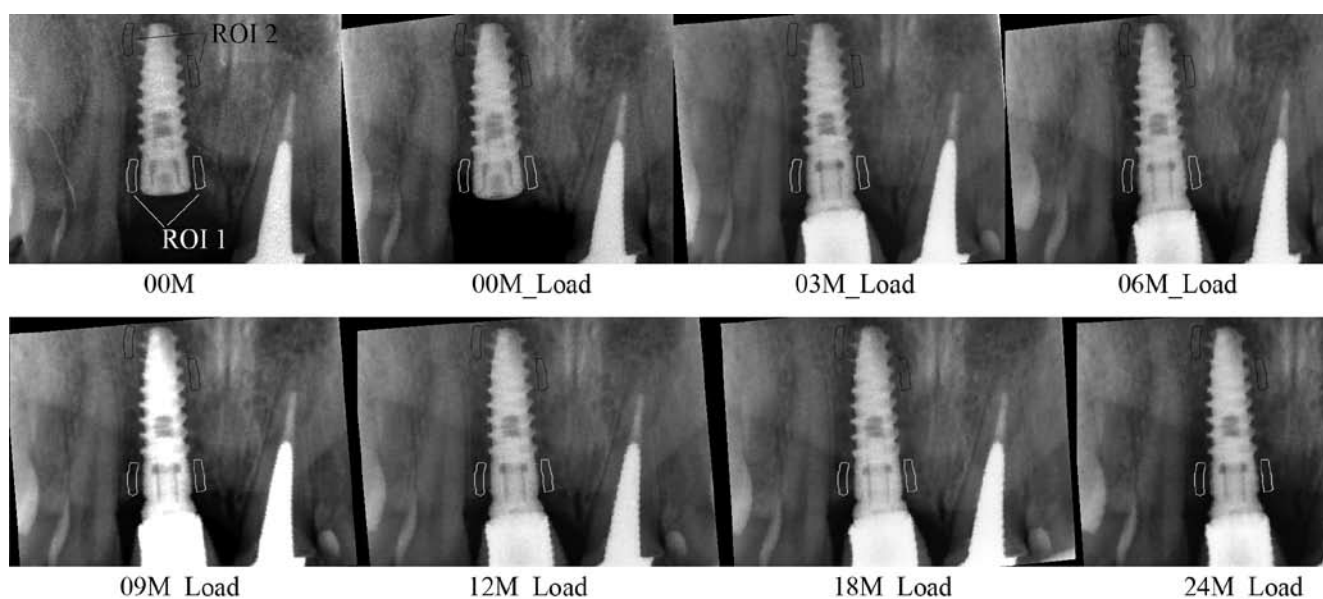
Series of analyzed radiographs with marked ROI1 [marginal crestal bone] and ROI2 [reference periapical bone] 00M – immediately post-operational, 00M_Load – just before functional loading, 03M_Load – 3 months after functional loading, 06M_Load – 6 months after functional loading, 09M_Load – 9 months after functional loading, 12M_Load – 12 months after functional loading, 18M_Load – 18 months after functional loading, 24M_Load – 24 months after functional loading.
